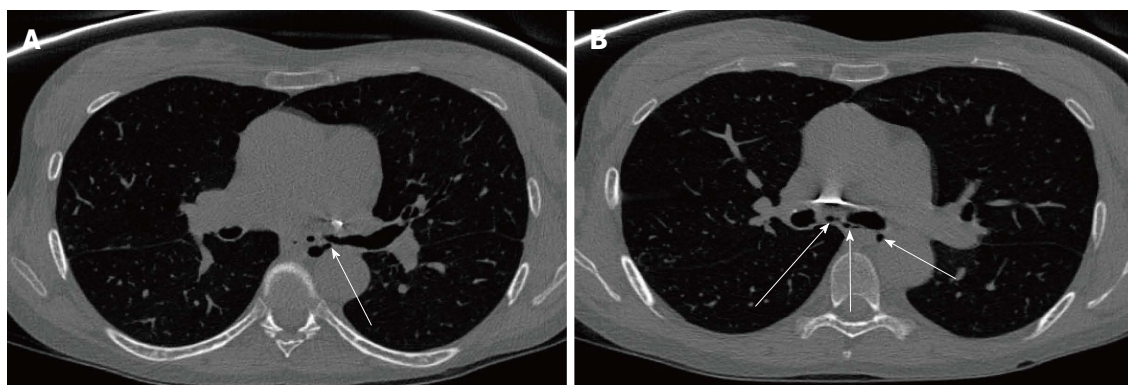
Computerised tomography scan of the chest in a 51-year-old female performed nearly 3 years post bilateral lung transplantation shows left main bronchial dehiscence resulting in gas locules tracking from the left main stem bronchus to the mediastinum causing pneumomediastinum. A: Axial slice of CT chest image showing gas leaks (arrow) from the left main stem bronchus; B: Axial slice of CT chest image showing multiple gas locules (arrow) causing pneumomediastinum. CT: Computerised tomography.
